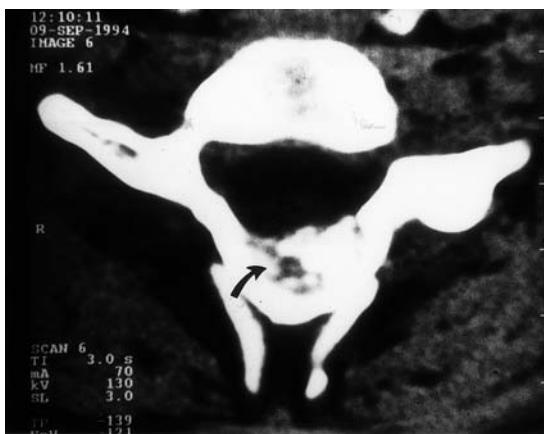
Osteoblastoma of C6 vertebral in a 15-year-old boy. The CT scan shows a destructive expansile lesion involving the spinous process and laminae with foci of mineralized-osseous matrix (*arrow*)
